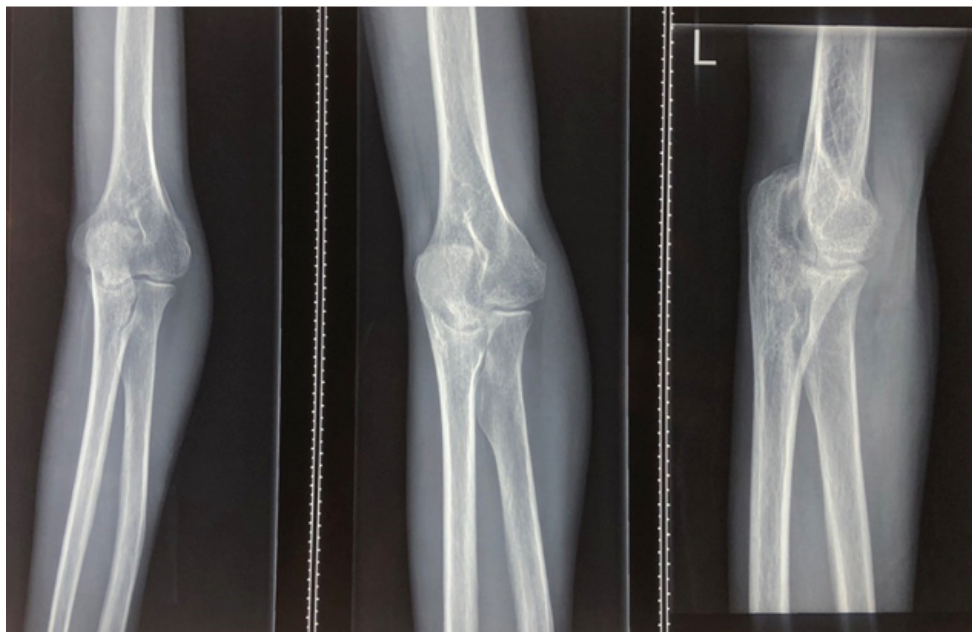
Radiographs of the left elbow: showing decreased joint space, Osteopenic bones and the lateral view shows ulnar bone osseous erosion.
